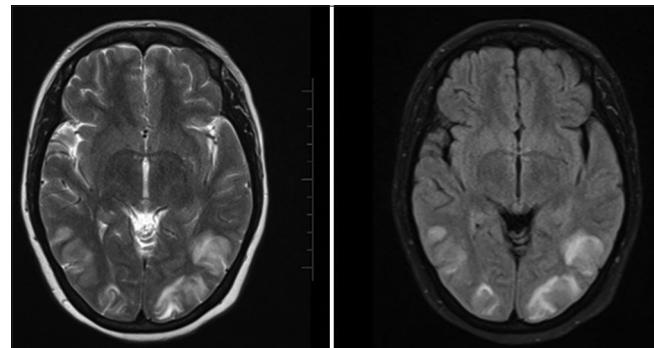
There are bilateral symmetrical T2 and FLAIR hyperintensities in the occipital region involving cortex and subcortex areas
